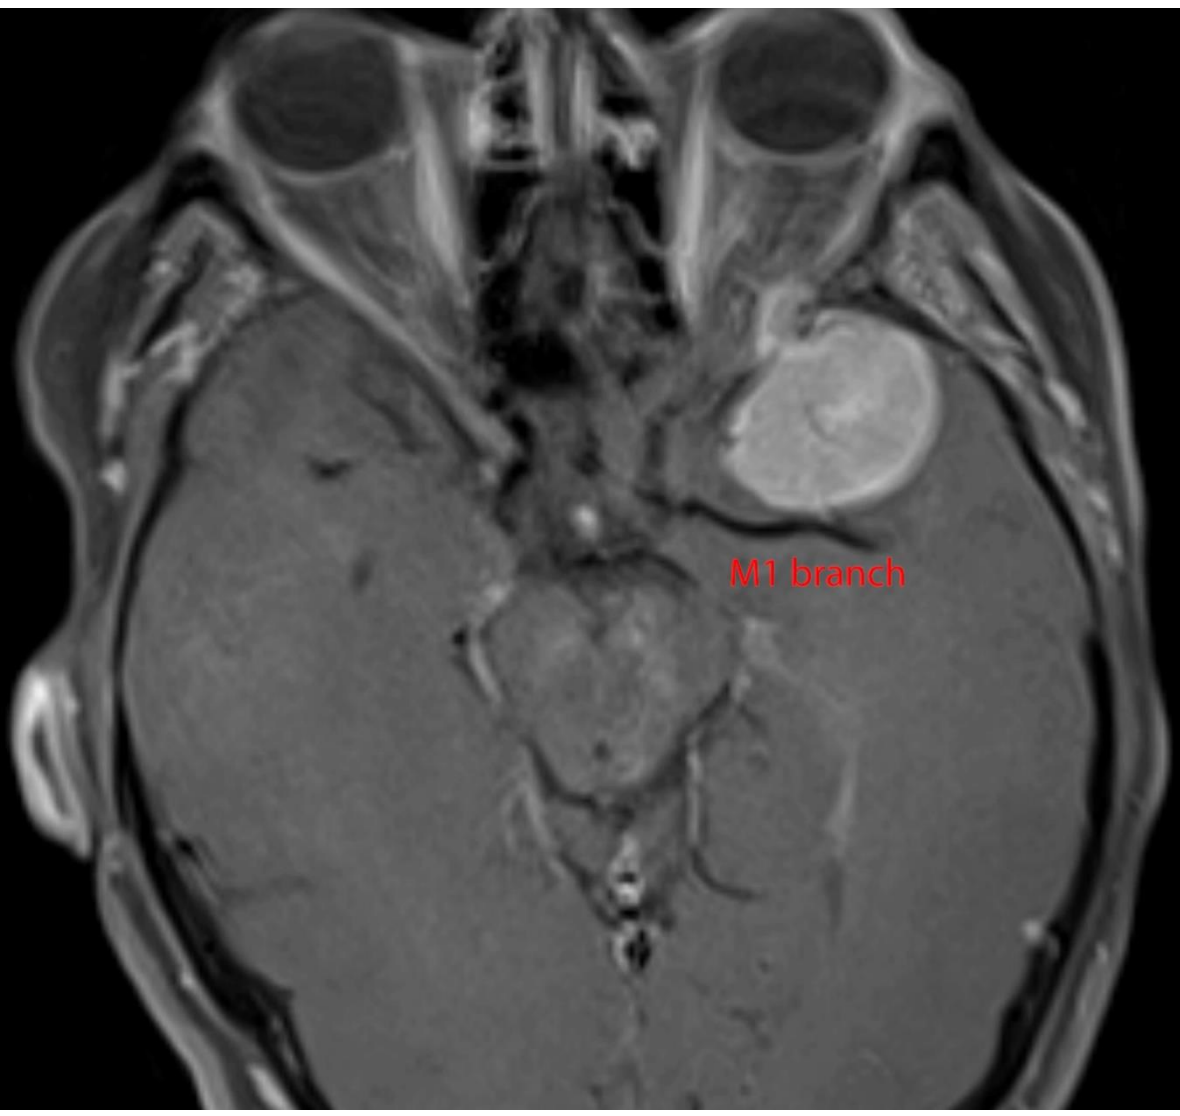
Preop axial T1 post-contrast MRI
